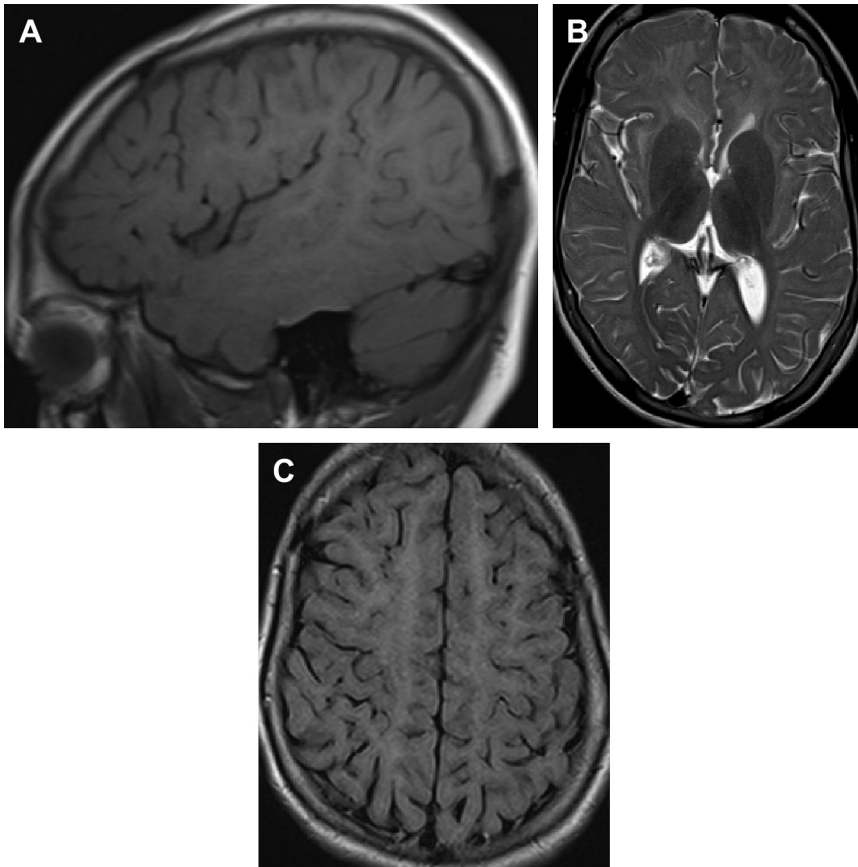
Fourteen-year-old boy with classic Pelizaeus-Merzbacher disease, diagnosed after nystagmus noticed at 4 months of age. Although there is some myelination visible on sagittal T1-weighted imaging (A), the myelination resembles that of an infant on axial T2-weighted imaging (B). The degree of abnormality is particularly conspicuous on the fluid attenuated inversion recovery image (C), which demonstrates diffuse white matter hyperintensity resembling a T1-weighted image.
